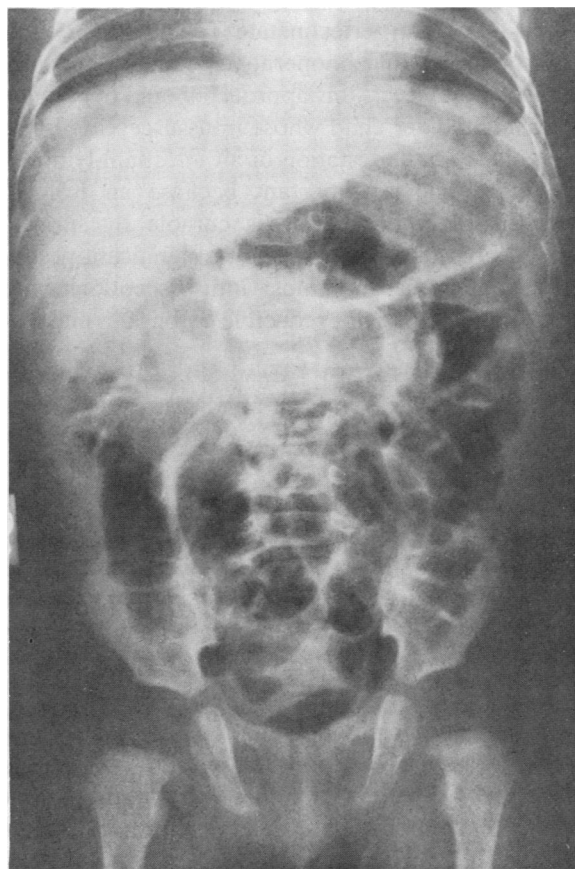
The plain roentgenogram is nonspecific. There are dilated loops of bowel throughout the abdomen.
